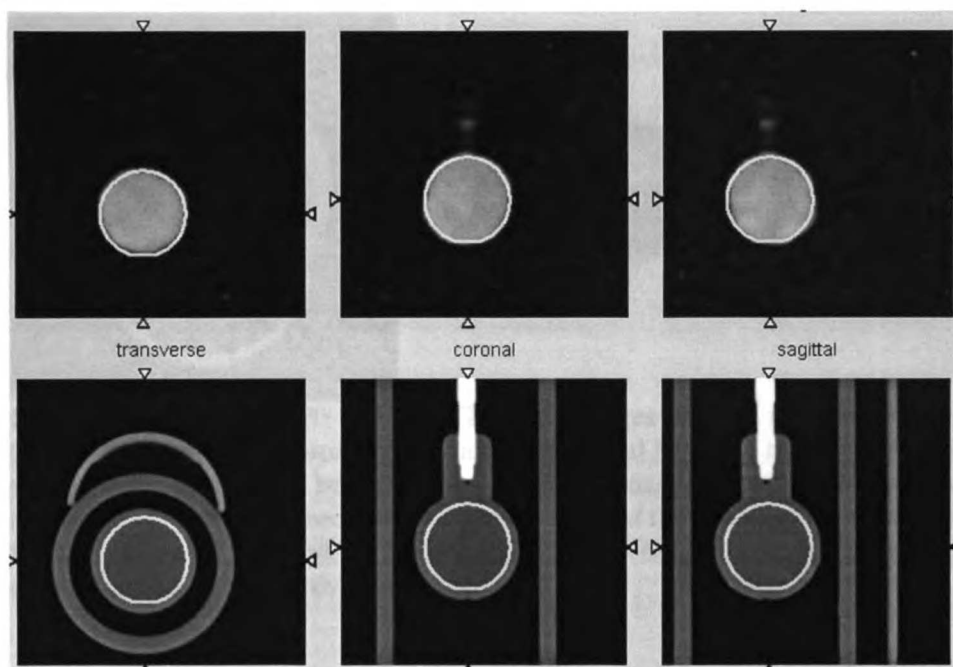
Reconstructed SPECT and CT images of a 2 mL microsphere filled with lutetium-177. The SPECT image is shown in the top row, with the corresponding CT images in the bottom row. Transverse, coronal, and sagittal slices are shown from left to right, with lines shown to define the region of interest in each image.
